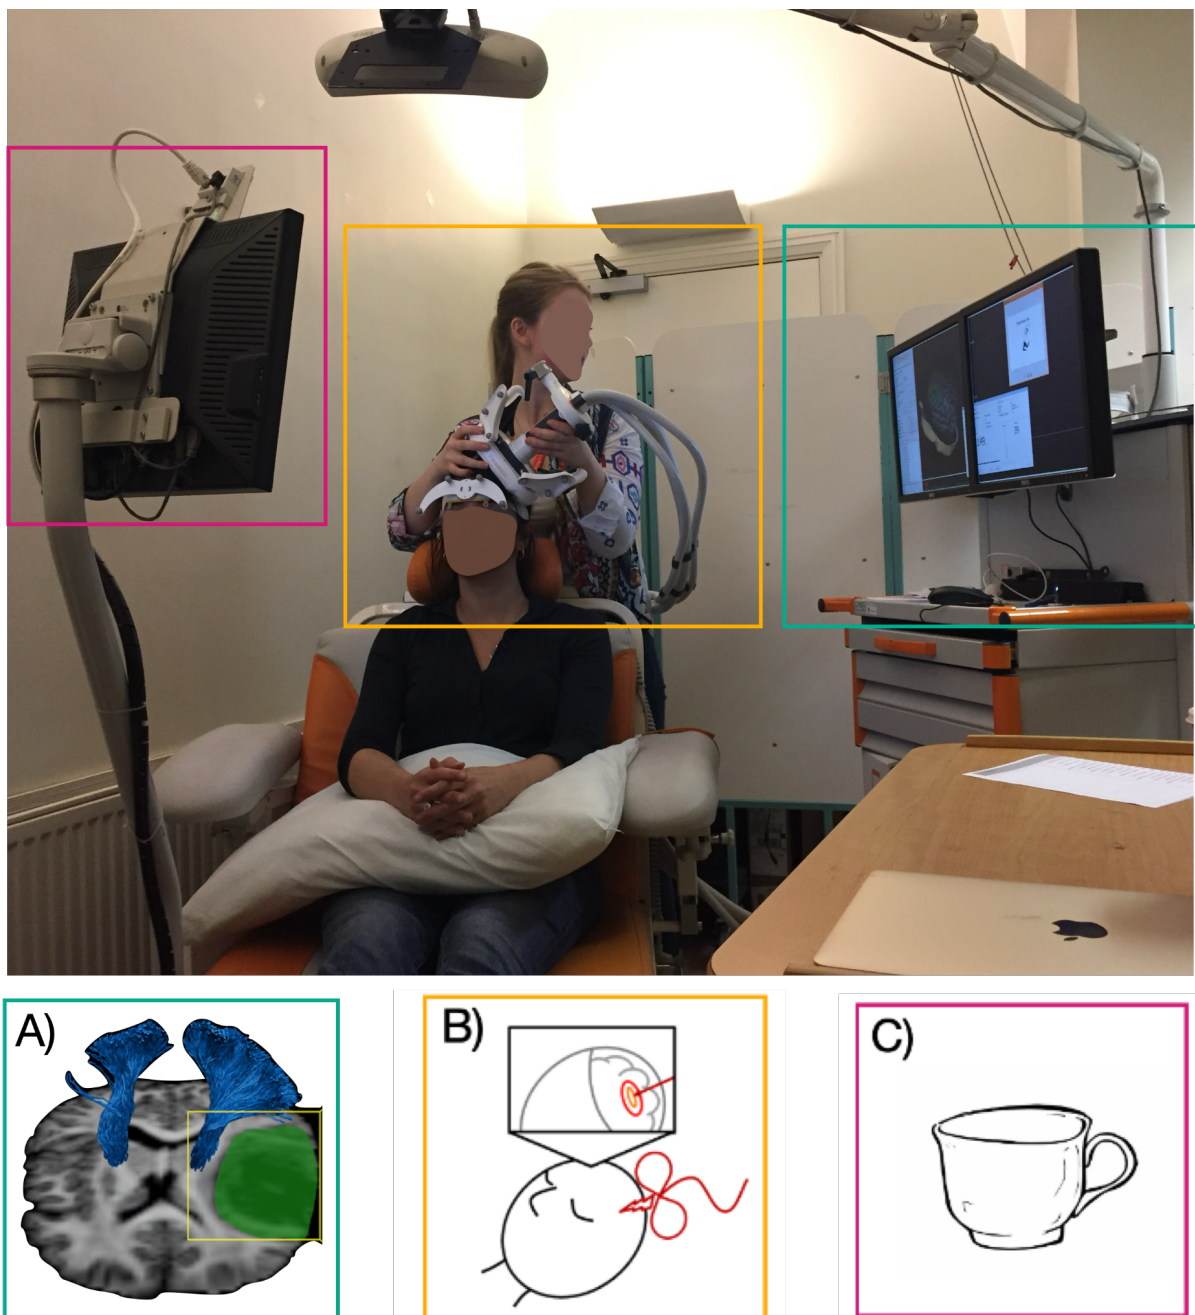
The clinical setup for presurgical language mapping using tractography and TMS. A) 3D-model of patient's neuroanatomy based on pre-TMS MRI scanning (including tumor entity) to aid coil placement and thereby TMS pulse on cortex, with the possibility to visualize a priori segmented tractography results. B) The experimenter places the stimulation coil on the head of the patient, guided by A). C) Patients view a screen where picture stimuli of a language task are presented (original artwork by Victor Xandri Antolin; © University of Groningen).
